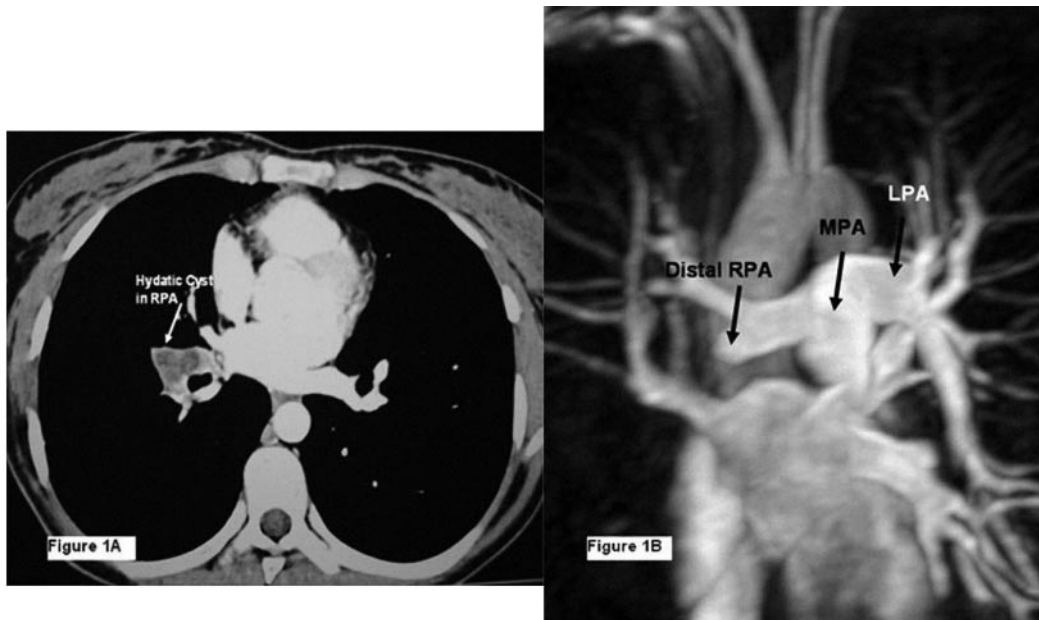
A, Computed tomographic image of hydatid cyst (arrow) occupying the right pulmonary artery (RPA) lumen. B, Magnetic resonance angiographic image showing obstruction of the distal part of the right pulmonary artery with a perfusion defect in the middle and lower branches of the RPA.
